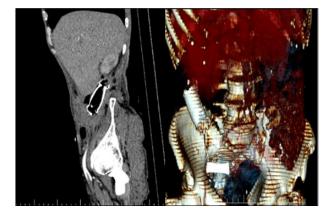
Computed tomography control demonstrating stent proximity to right abdominal wall.
